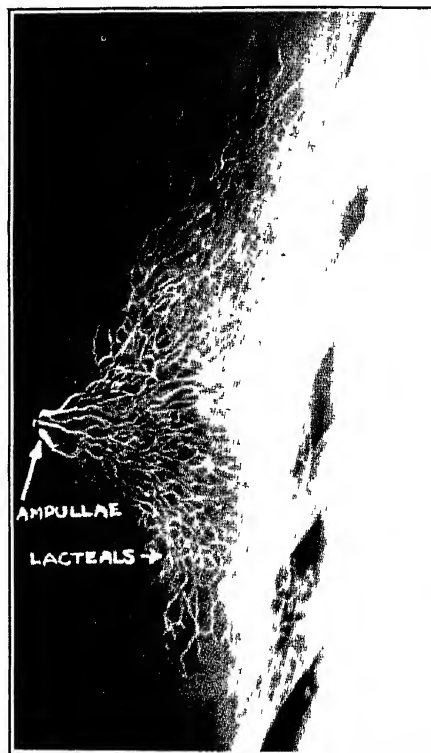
Virginal breast. A retouched mammogram showing the ramifying lacteals. The ducts are small, the ampullae are not dilated and the acini are not developed (Am J Roentgenol, March, 1938.)
